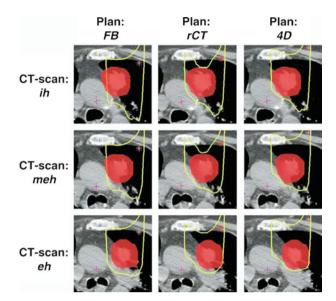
Treatment planning for proton therapy of a lung tumor. 4D-CT images were used to account for intrafractional motion. Dose distributions for 1 of 3 beam directions and for three treatment plans calculated on end-inhalation (ih), mid-exhalation (meh), and end-exhalation (eh) phases are shown. The three plans were created for a CTV constructed from a normal free-breathing CT including margins (FB), from the 4D motion for a CTV derived from a reference image in mid-exhale phase with the same margin as in FB (rCT), and a CTV derived from all three breathing phases encompassing all possible target positions (4D). The *yellow line* indicates the 95% isodose level, the *red* area the CTV. Plan FB does not cover the target volume over all breathing phases. Plan rCT slightly underdoses the target in some slices. Target coverage is best for plan 4D. Reprinted from [19]
